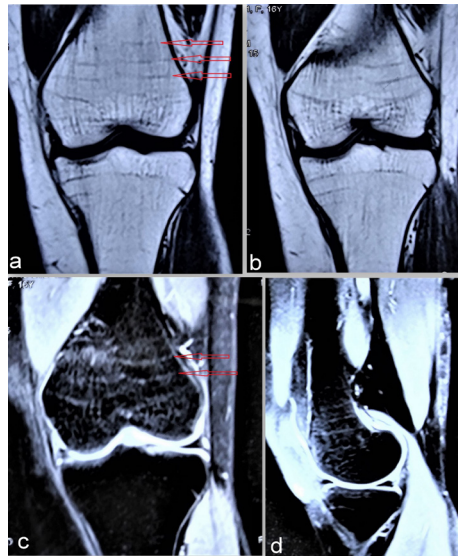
The MRI coronal plane images show multiple parallel transverse dark lines in the distal femur metaphysis (arrows), with few present in upper tibia metaphysis (a, b). In contrast the images (c, d) show these bands in the fat-suppressed sequence in the coronal and sagittal plane, respectively.
